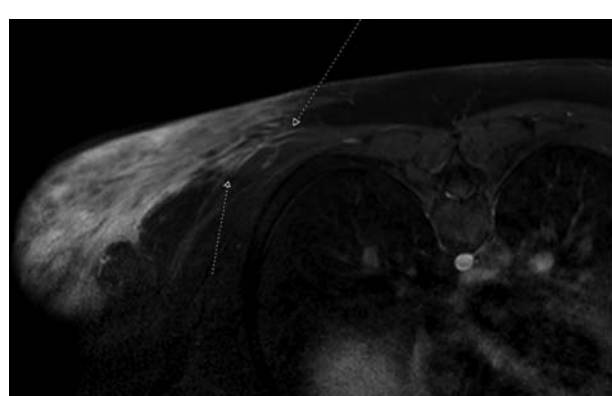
Magnetic resonance imaging shows the feeding vessels, indicated by the arrows, going into the back mass
